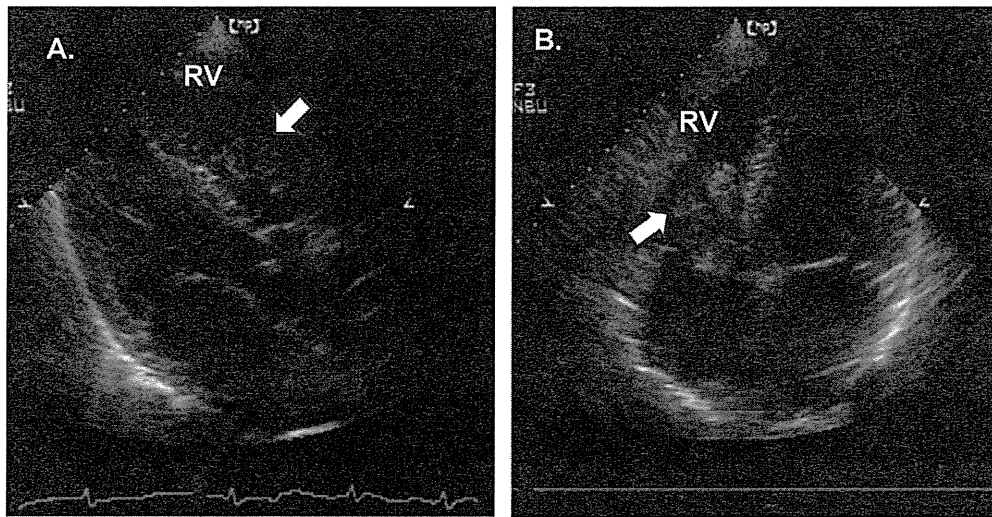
Echocardiogram of axis view (A) and four chamber view (B). A giant floating thrombus (3 cm x 3 cm, white arrows) in the right atrium and ventricle frequently moved back and forth through the tricuspid orifice. RV, right ventricle.
